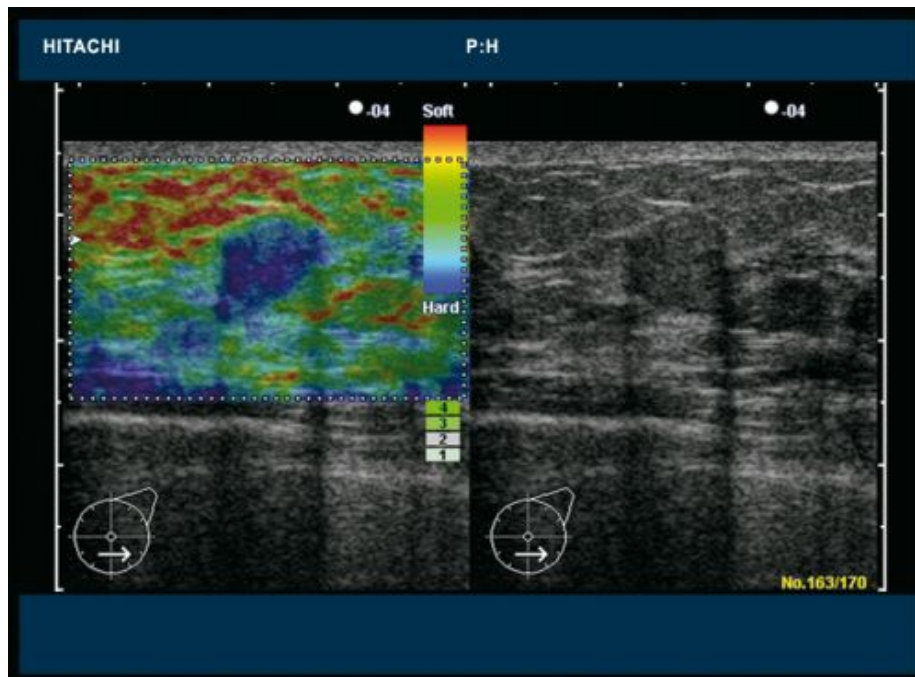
Example image showing a use of strain elastography with breast ultrasound. The red region of the map is representative of softer tissues with the blue region of the map indicative of stiffer tissue.
